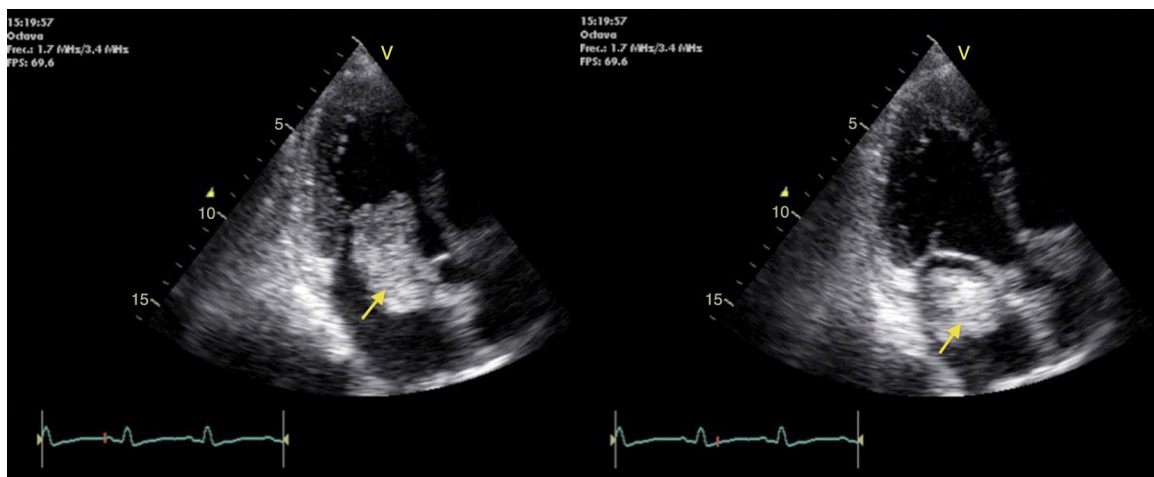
Transthoracic echocardiogram with an apical view of 3 chambers showing a tumor in left atrium, in diastole (left) and in systole (right).
